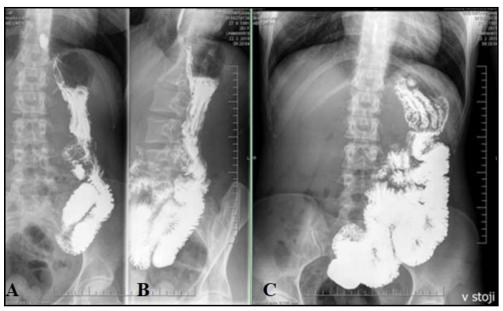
X-ray passage of the upper gastrointestinal tract showed an accelerated gastric emptying (A in 0. minute, B in 30. minute, C in 60. minute)
